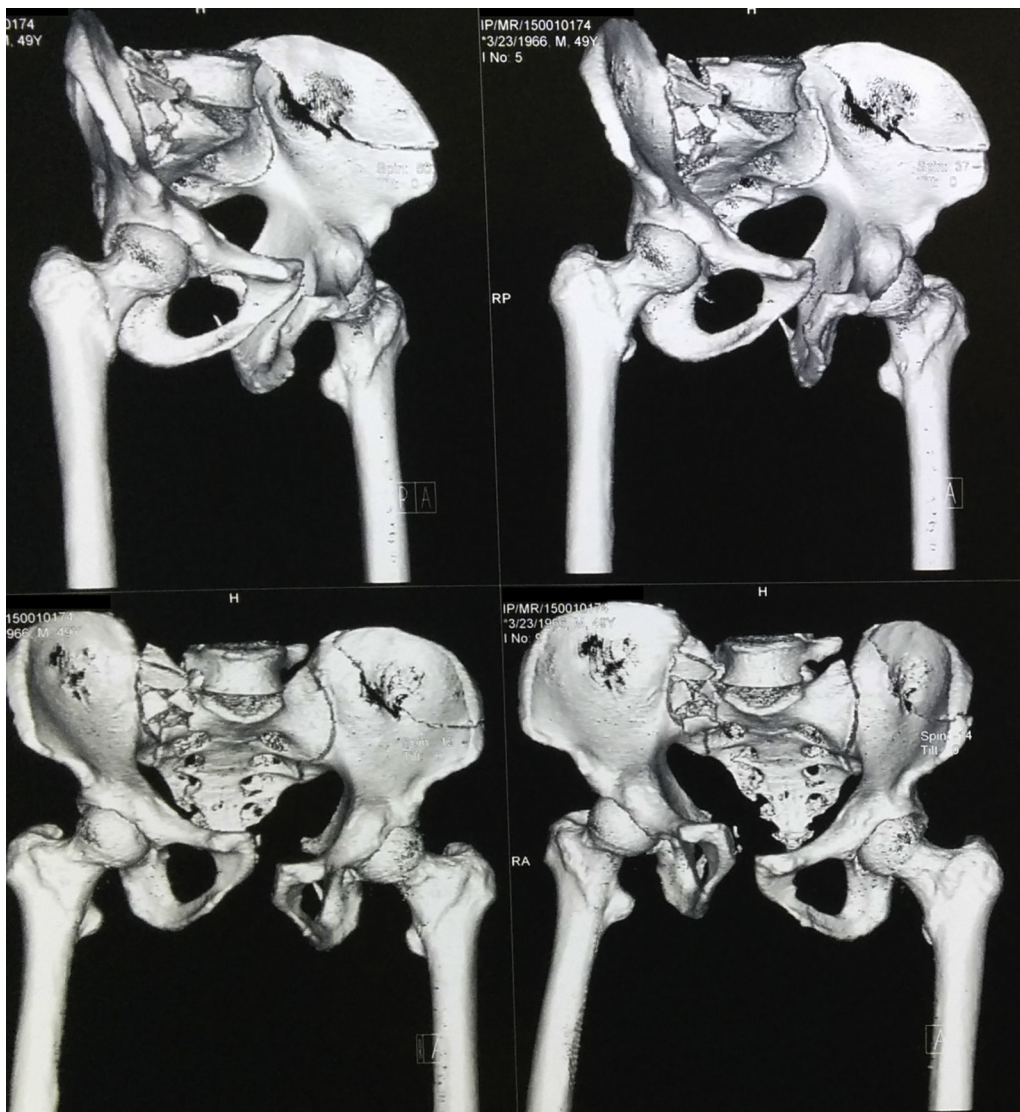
3D-CT scan images showing AO type 61-C1.3 injury.
